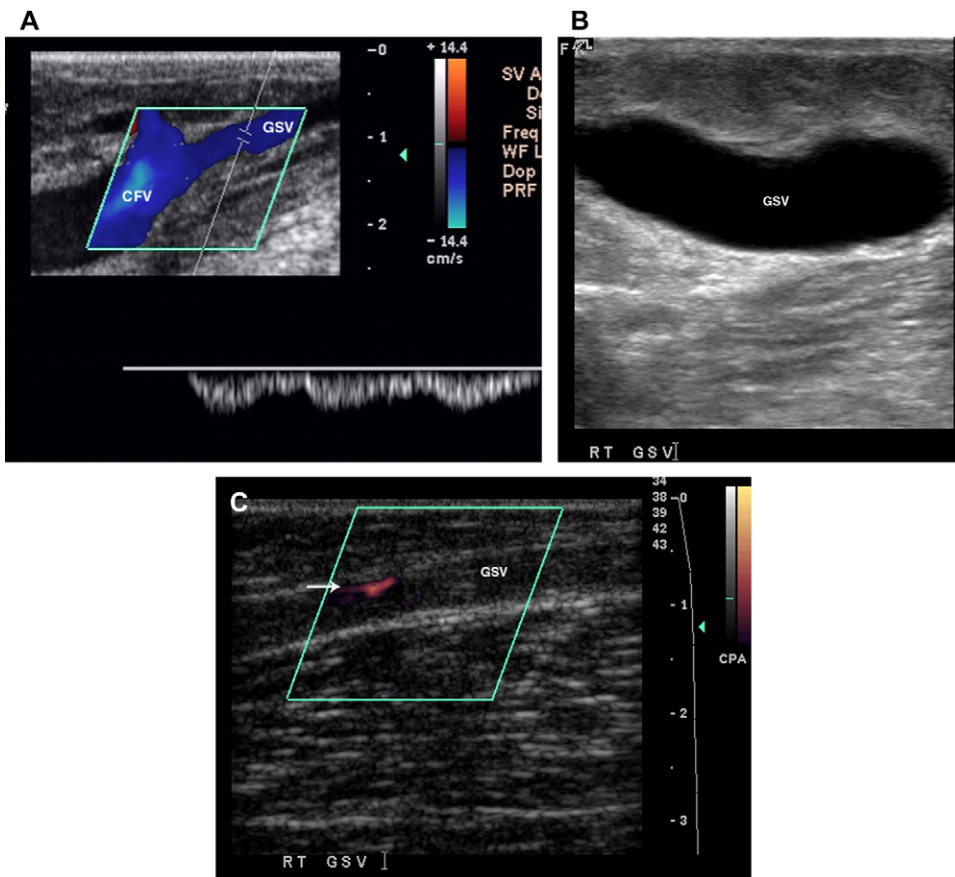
(A) Normal greater saphenous vein/common femoral vein junction—Doppler gate in greater saphenous vein. (B) Large greater saphenous vein in a patient who has congestive heart failure. (C) Sagittal US of thrombosed greater saphenous vein with only a trickle of peripheral flow (arrow).
